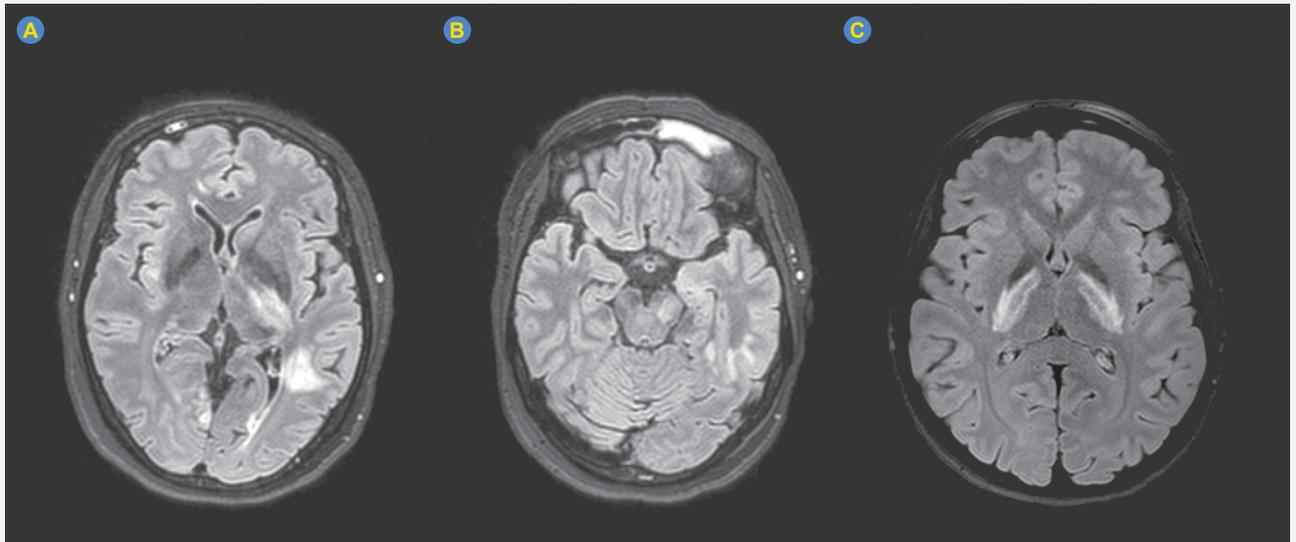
Exemplos de ressonância magnética cerebral em doentes com neuro-Behçet. Áreas de hipersinal em T2 e T2/FLAIR em topografia justacortical e nas coroas radiadas (A), na amígdala temporal e cabeça do hipocampo à esquerda, com atingimento profundo da cápsula interna e transição tálamo-mesencefálica à esquerda (B), núcleos lentiformes e tálamos bilateralmente (C).
